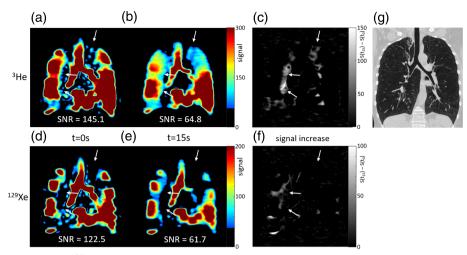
³He images (top) and ¹²⁹Xe images (bottom) acquired from patient 2 during breath-hold; (a,d) at the start of the imaging sequence, t = 0 sec, and (b,e) after 15 seconds, both shown with the same signal range. (c,f) Maps of signal increase from t = 0 sec to t = 15 sec. White arrows highlight regions of lung where ³He signal increased over time, but ¹²⁹Xe signal did not. (g) CT showed severe centrilobular emphysema and severe hyperinflation, and all fissures appeared intact. Mean SNR over the whole lung ventilated volume for that timepoint is displayed for a, b, d, and e.
